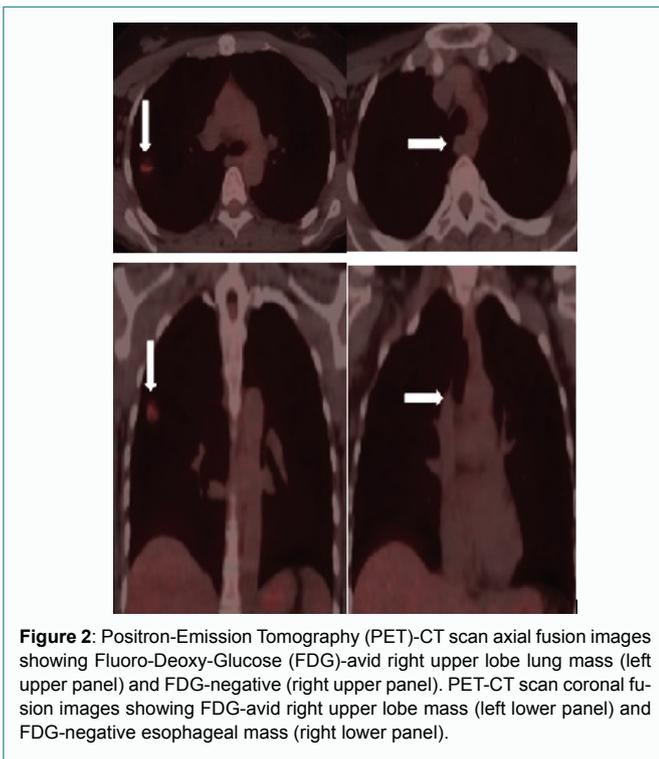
Positron-Emission Tomography (PET)-CT scan axial fusion images showing Fluoro-Deoxy-Glucose (FDG)-avid right upper lobe lung mass (left upper panel) and FDG-negative (right upper panel). PET-CT scan coronal fusion images showing FDG-avid right upper lobe mass (left lower panel) and FDG-negative esophageal mass (right lower panel).
